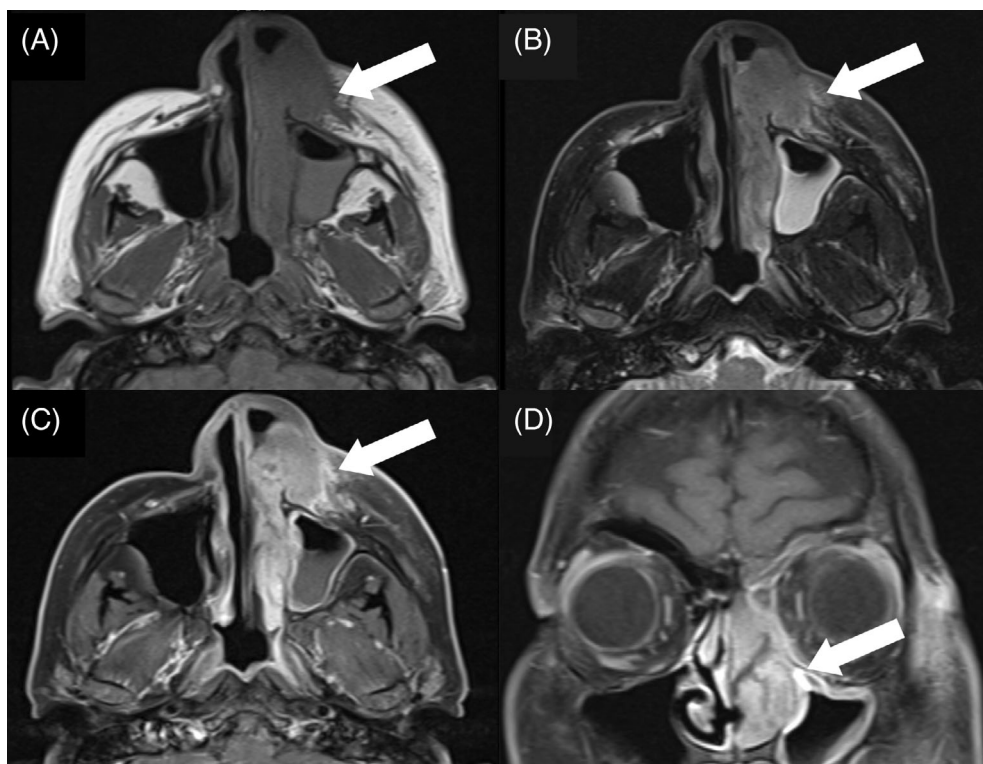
A 47-year-old female presenting with painless left-sided nasal and facial subcutaneous mass found to have SN-ENKTL. (A) Axial T1-weighted, (B) axial T2-weighted, and (C) axial and (D) coronal T1-weighted post-contrast with a left nasal cavity mass involving the soft tissues of the nose, left inferior and middle turbinates, left nasolacrimal duct and left inferomedial orbit (white arrow)
